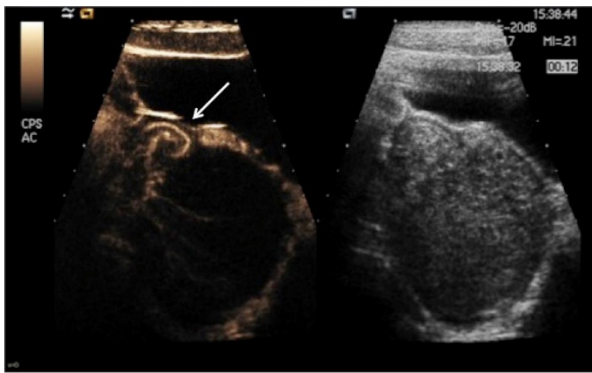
CEUS and B-Mode ultrasound: ovarian torsion with twisted vascular pedicle (arrow), enlarged ovary and abnormal enhancement of the ovarian parenchyma.
